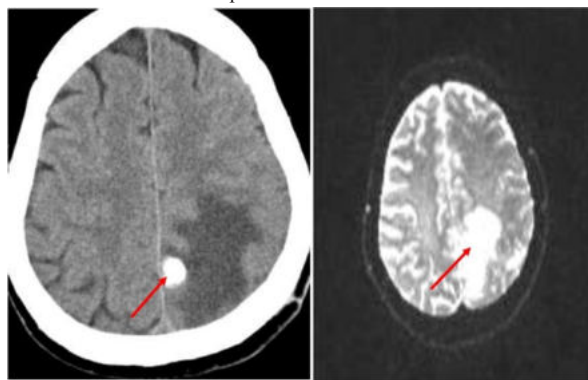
CT and MRI BRAIN
